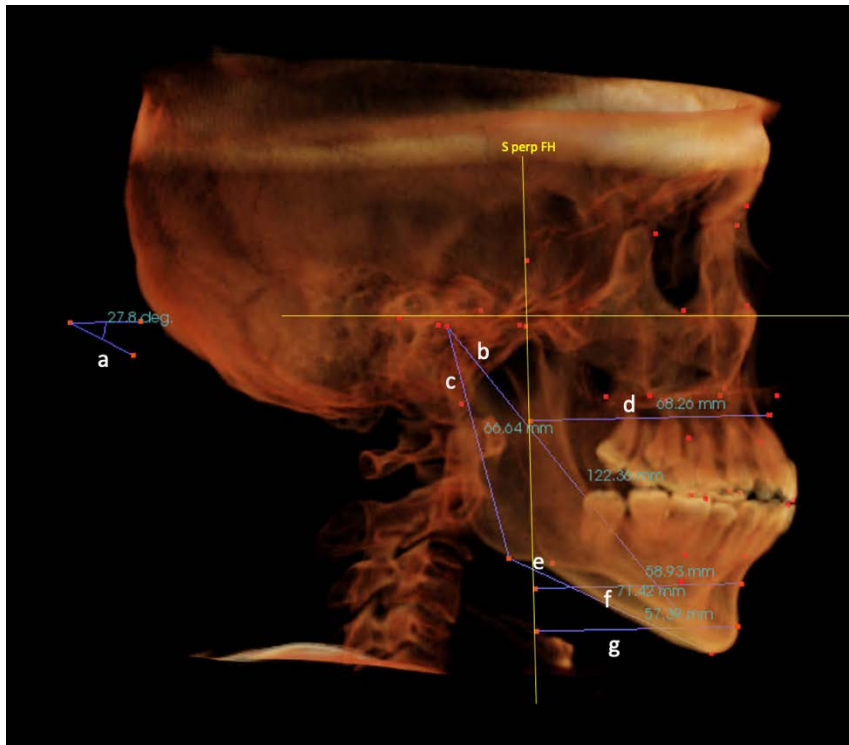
CBCT Measurements: a, FMA; b, Mandibular length; c, Mandibular ramus length; d, Sella perpendicular A; e, Mandibular body length; f, Sella perpendicular B; g, Sella perpendicular Pogonion.
